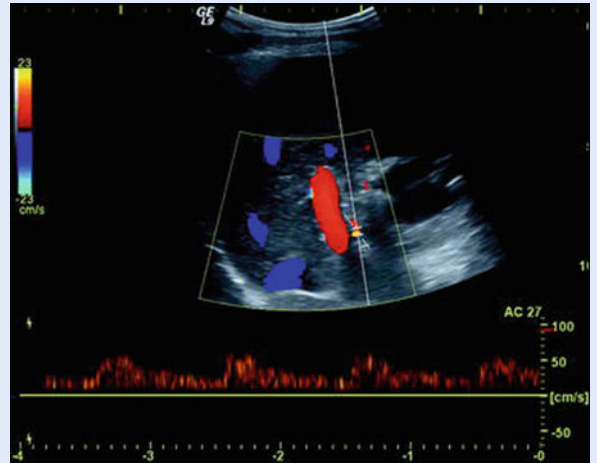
Color Doppler waveform spectrum of the hepatic artery shows the normal monophasic, low-resistance with high diastolic flow arterial pattern
